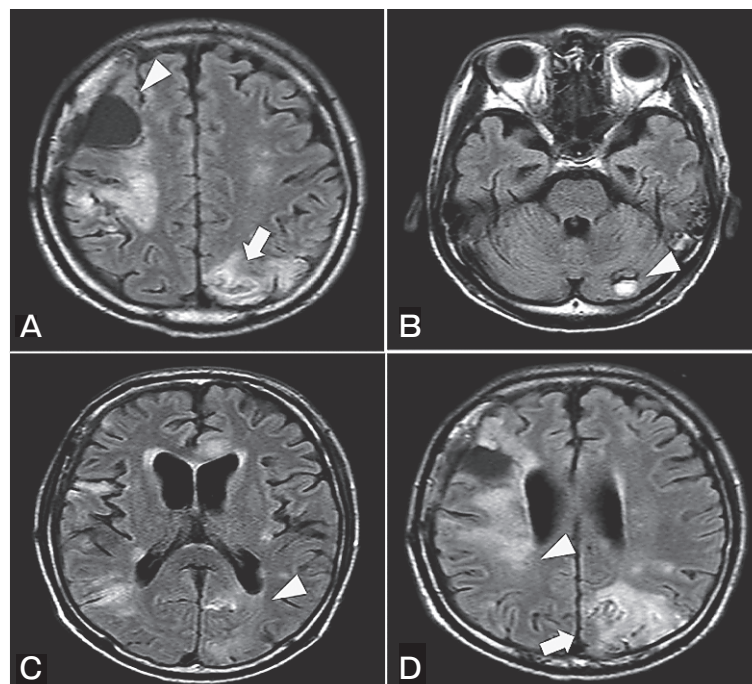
MRI (FLAIR long TR) findings after lenvatinib initiation. A, No apparent recurrence in the resected area of the frontal lobe (arrowhead), but new lesions appeared in the occipital lobe (arrow); B, The cerebellar lesion showing no remarkable change (arrowhead); C, D, The small new lesions had almost disappeared (arrowheads), but multiple edematous changes appeared as a result of increased brain metastases (arrow).
